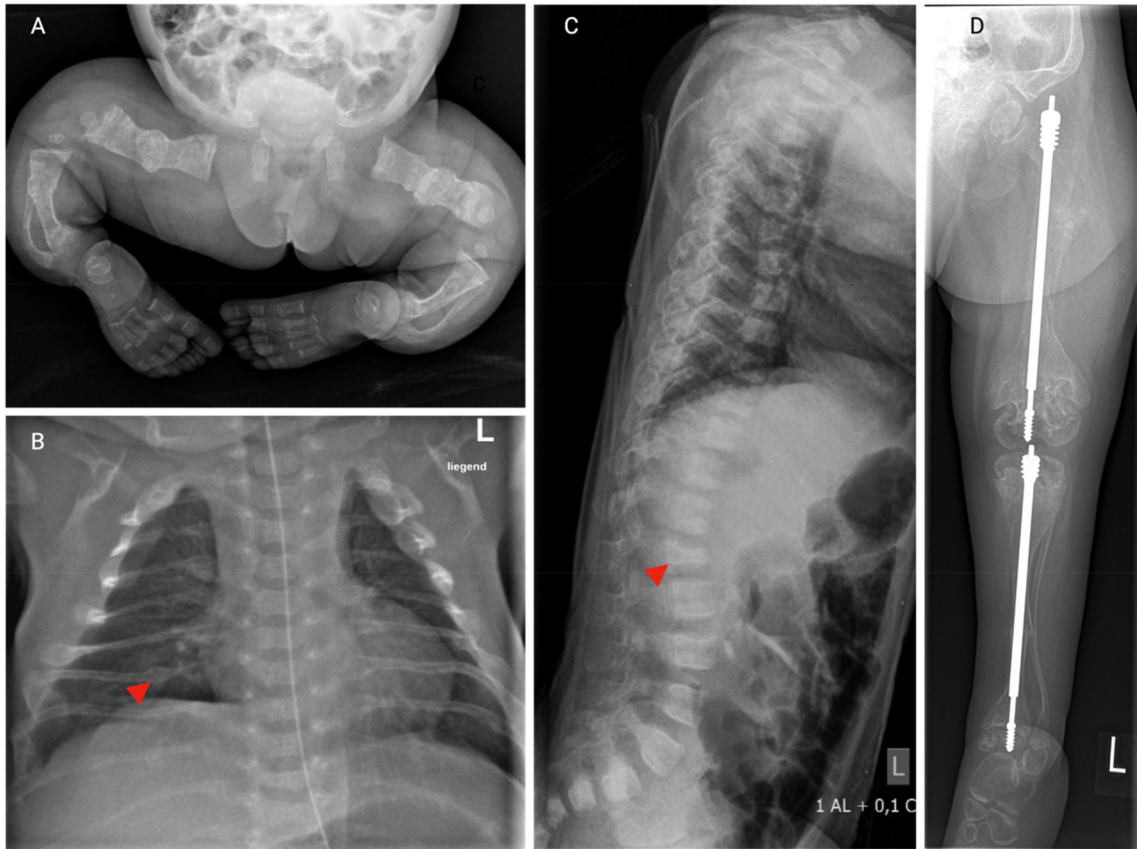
Skeletal manifestations of OI. Series of X-rays from a young girl with severe OI type VIII. (A) X-ray of the lower body 3 days after birth showing multiple healed fractures, generalized osteopenia, bowing and shortening of the long bones. (B) Chest X-ray 3 days after birth. Notice the thin ribs with irregularly shaped, thickened areas (arrow head) consistent with healed fractures. (C) Lateral X-ray of the spine in the age of 1.5 years reveals flattened, irregularly shaped vertebral bodies (arrow head), indicative of compression fractures, along with pronounced kyphosis. (D) X-ray of the lower extremity in the age of 5 years after surgical insertion of telescopic nails in the tibia and femur. Notice the generalized osteopenia, thin cortical bones, multiple fractures in the tibia and femur, and bowing of the thin fibula. The distal metaphyses of the femur appear wide and irregular.
